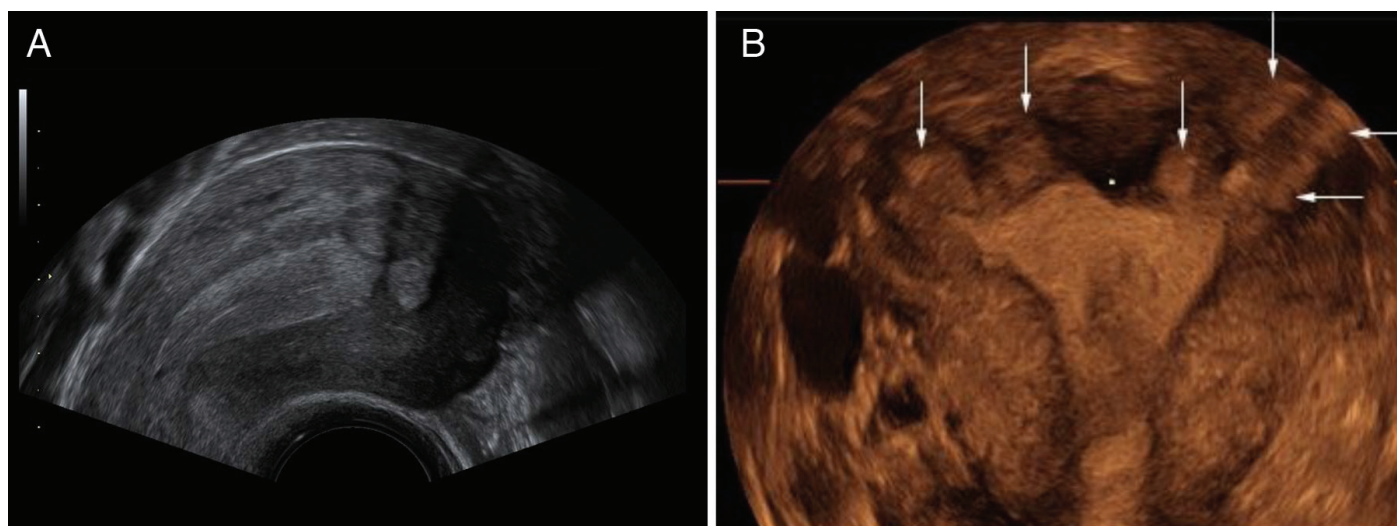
(A) This ultrasound image - a sagittal section through the uterus - shows adenomyotic lesions close to the endometrium. Characteristically, these lesions have the same echogenicity [extracted from (37)]. (B) In the coronal plane the three-dimensional transvaginal ultrasound investigation shows several adenomyotic lesions arising from the endometrium close to the fundus [extracted from (37)]
